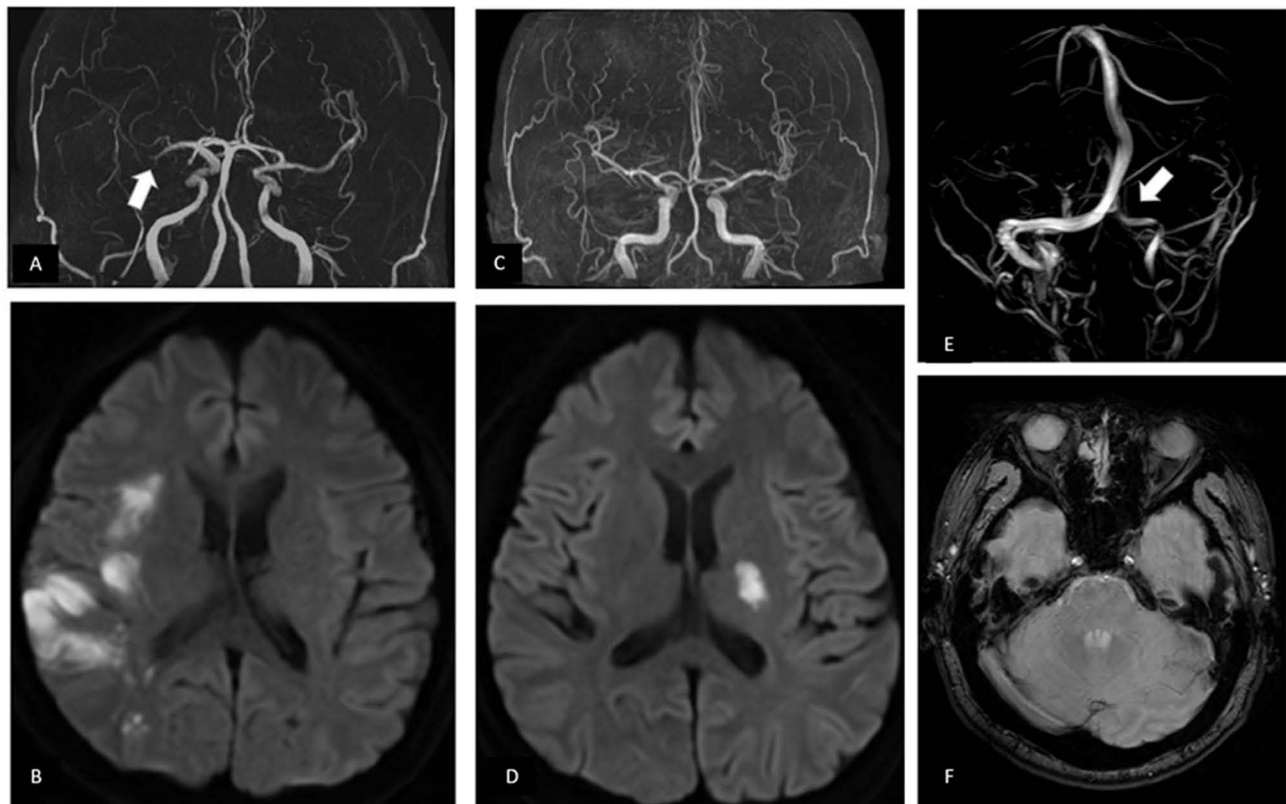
An example of large vessel disease of a 52-year-old male with left hemiparesis. TOF-MRA shows occlusion on the 2nd branch of the middle cerebral artery (M2) (white arrow) heading to inferior posterior area (A). DWI sequence shows restricted diffusion at the external capsule and Wernicke's areas (B). An example of small vessel disease showing on a 40-year-old male with right hemiparesis. TOF MRA shows no visible occlusion in TOF-MRA (C) despite a visible lesion at the internal capsule on DWI sequence (D). TOF-MRV shows hypoplasia of the left sinus transverse, sigmoid, and jugular vein (white arrow) confirmed in T2 axial plane (E).
